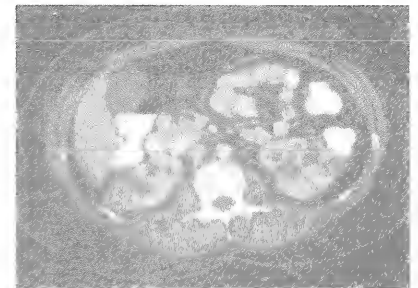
CT scan showing polycystic kidneys.
